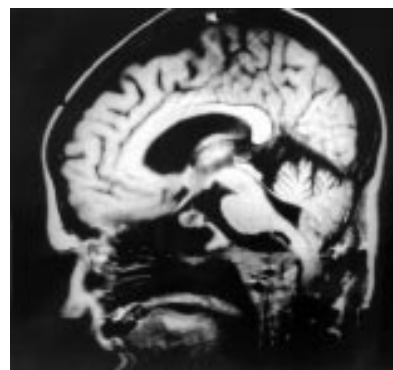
Preoperative T1 weighted sagittal MRI, showing cerebellar tonsillar invagination and angulation of the upper medulla, and abnormality of the dens and posterior arch of C1.
